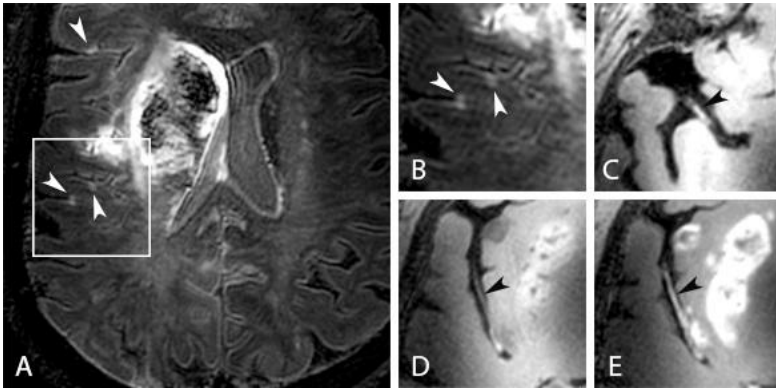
(A)FLAIR shows infarct and CMLs; zoomed view(B). Vessel wall images show thickening(C+D) and enhancement(E) of the right M1(C) and M2(D) segments
